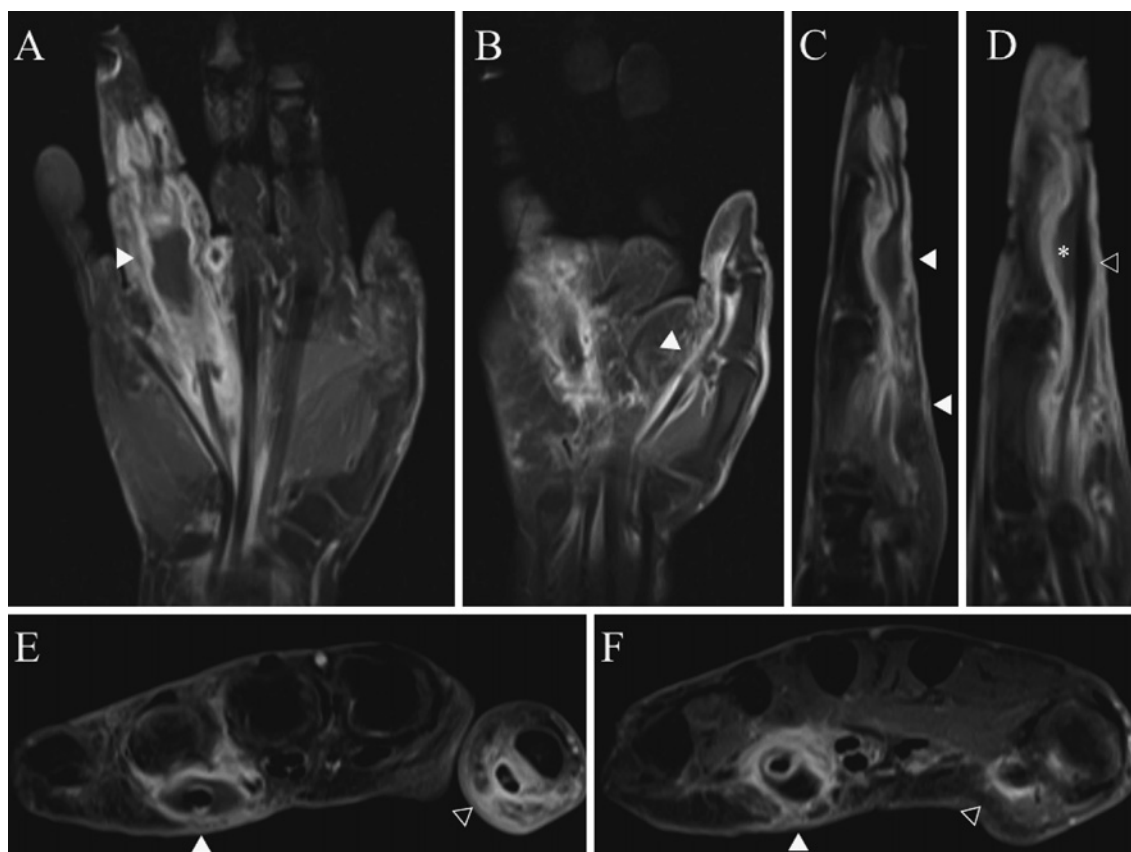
Magnetic resonance image of the left hand showing enlargement and swelling of the left fourth finger and thumb, with high signal intensity on enhanced T1-weighted images.
